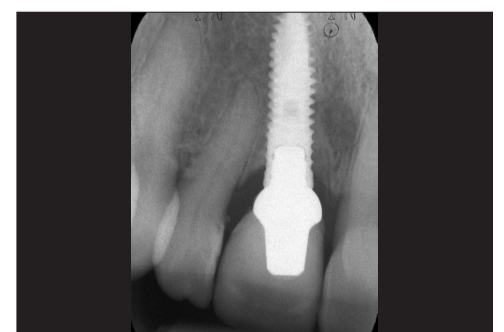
Postoperative radiograph with final restoration.
